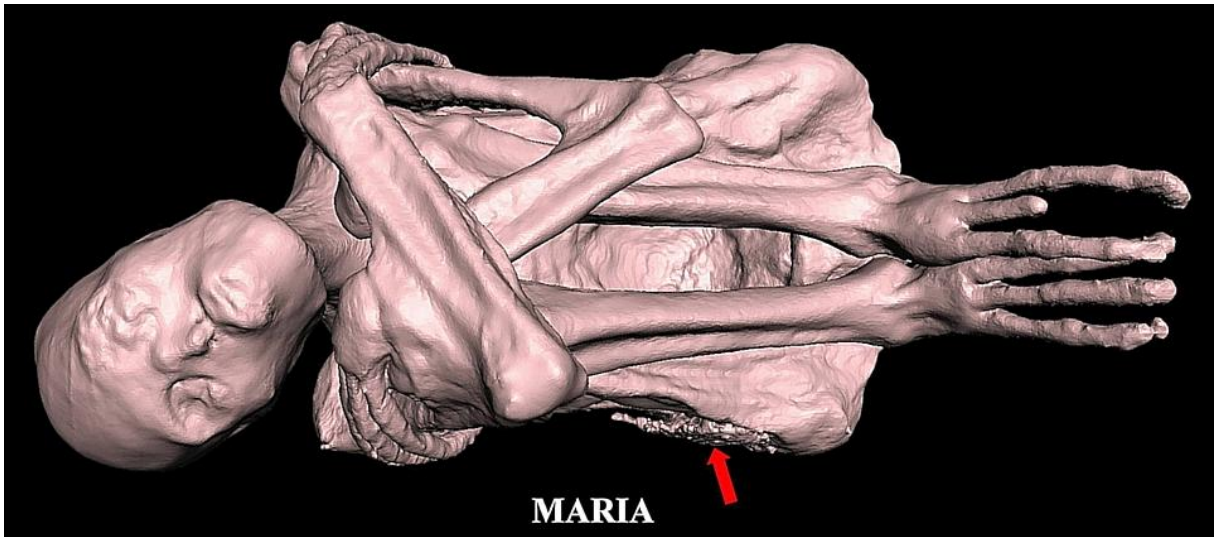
3D CT showing 'Maria' lying on right side. A layer of extraneous material was found in her right iliac region (*red arrow*).
